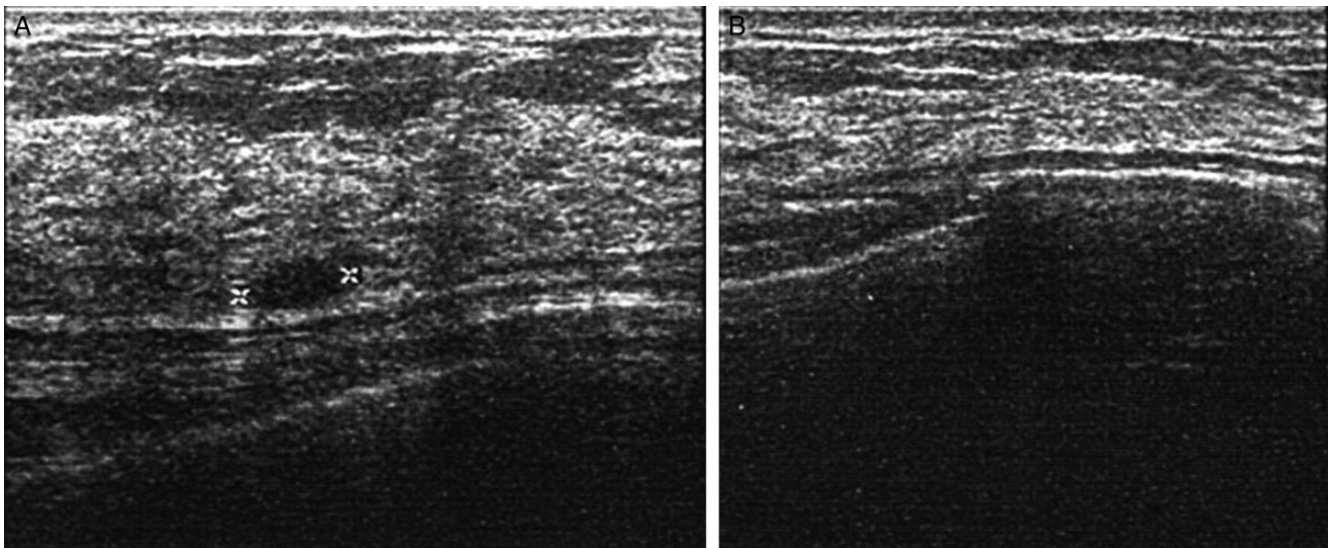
(A) Preoperative and (B) 6-month postoperative breast ultrasounds of this 47-year-old woman who underwent removal of Macrolane-containing cysts and breast augmentation. Note removal of cysts containing Macrolane in the postoperative sonogram.
